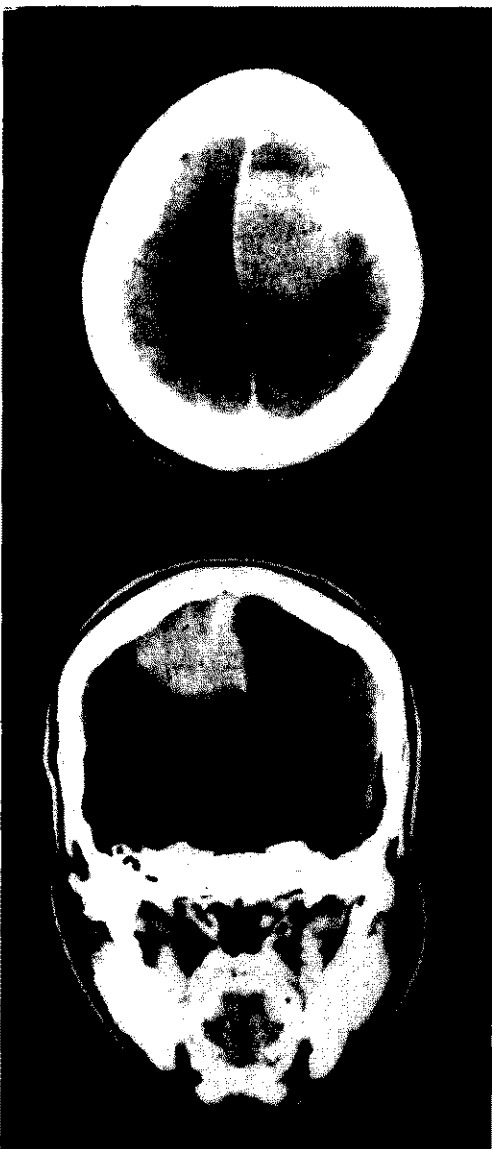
Parasagittal meningioma in 42-years old female. Coronal and axial contrast-enhanced CT images, showing well-defined uniformly enhancing mass.
